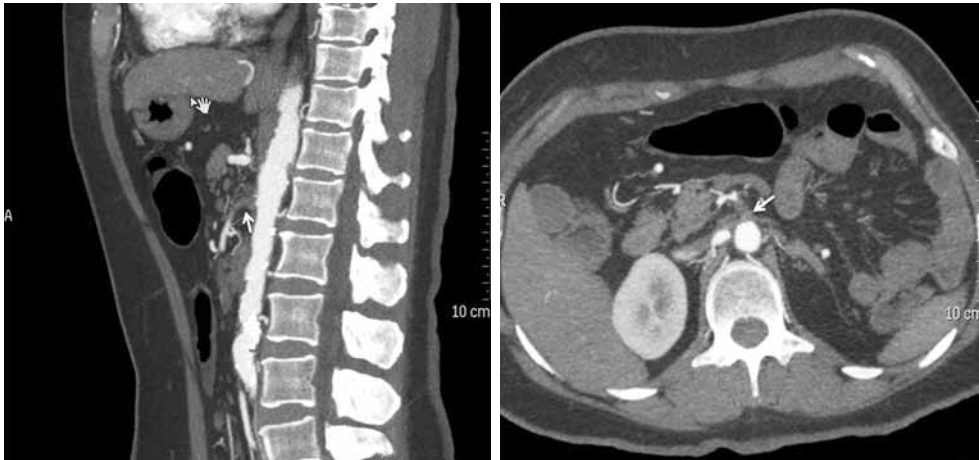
Computed tomography angiography demonstrates the occlusion of the origin of the superior mesenteric artery. The arrows indicate the occlusion.
